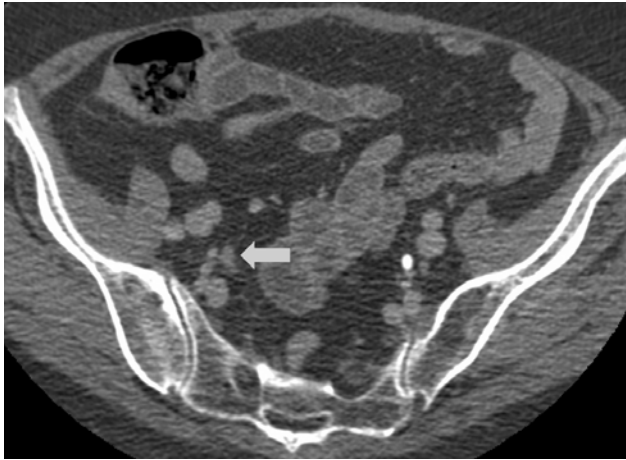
Excretory-phase CT urography showing non-opacification of the right ureter without dilatation.
